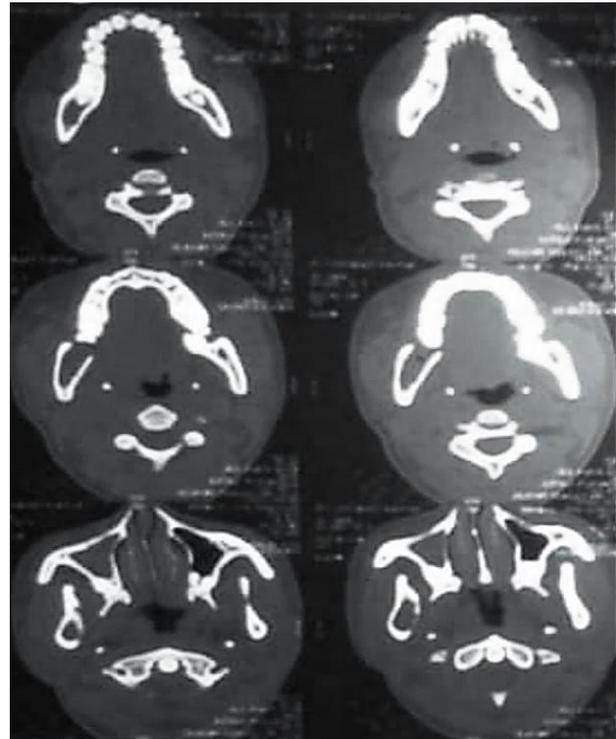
Axial CT showing left posterior mandibular ramus hypodensity.
